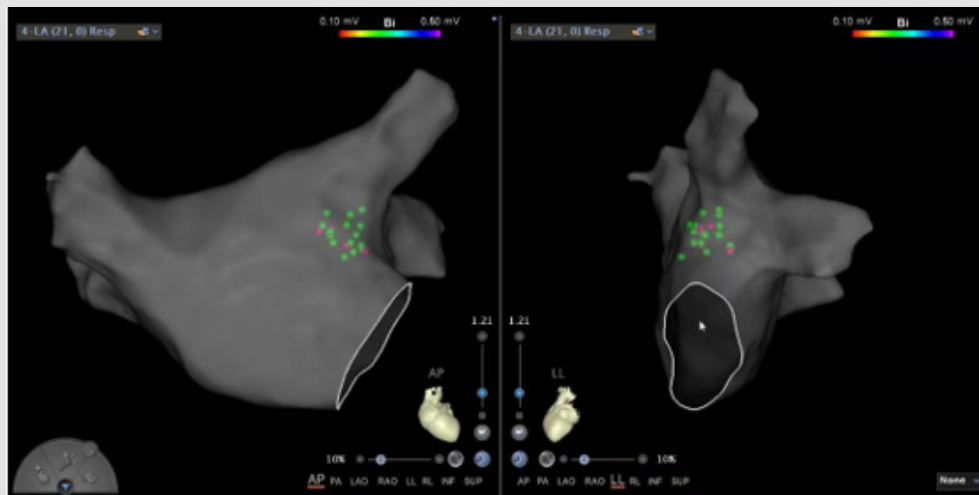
Left atrial CTA/MRI and Carto-3 electroanatomical mapping system fusion, respectively, and reconstruction was performed.
